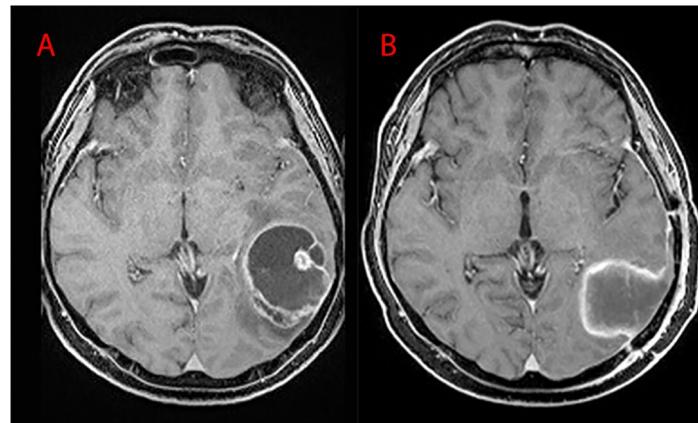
MRI T1WI axial section. (A) preoperative right frontal Glioblastoma (B) post operative images (extent resection 90-100%, STR).
